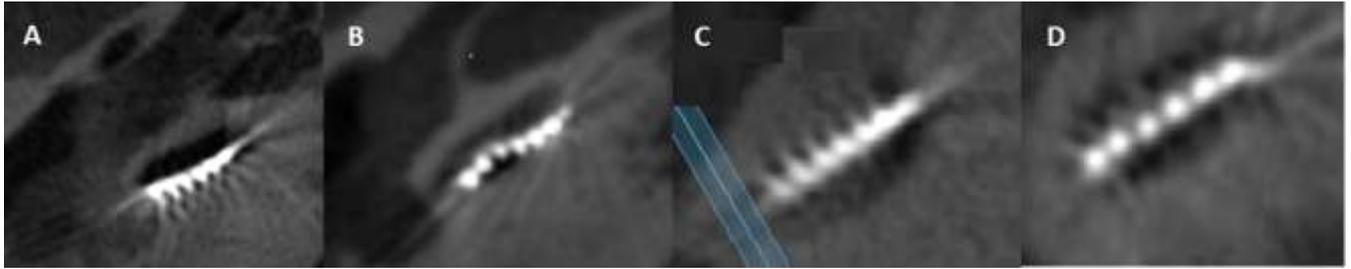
Cone-beam computed tomography (CBCT) image of the basal turn of the cochlea with an implanted electrode array showing the four categories based on location of basal electrodes: (a) scala tympani, (b) translocated, (c) scala vestibuli, and (d) undetermined.
